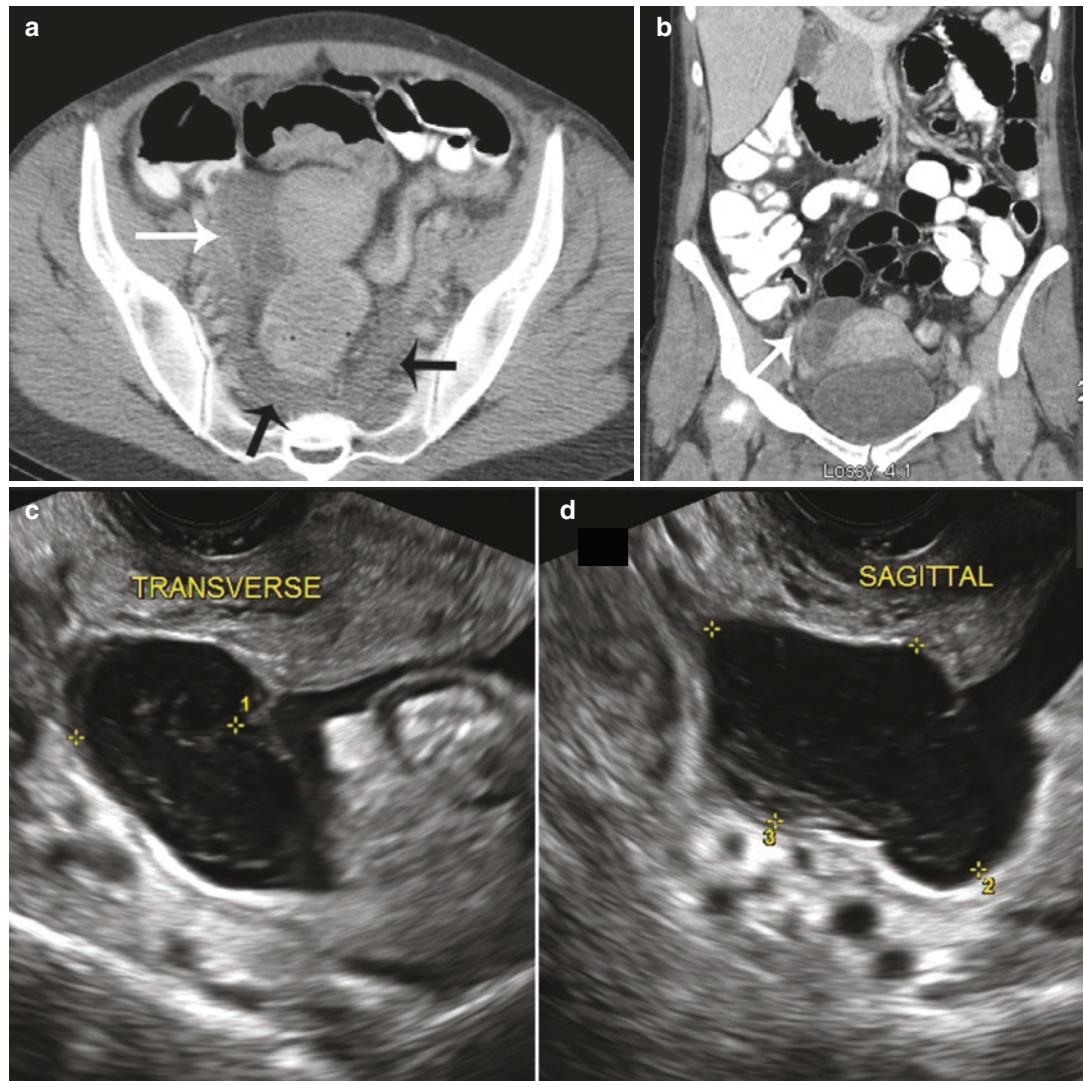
(a) Axial CT image with oral and IV contrast of an 18-year-old woman who presented with a 1-week history of worsening pelvic pain. Diffuse fluid and inflammatory changes were seen in the pelvis (arrows). (b) A dilated tubular structure on the right (white arrow, (a, b); (b) – coronal CT image) was thought to represent an abnormally dilated fallopian tube. At surgery, this tubular structure was
